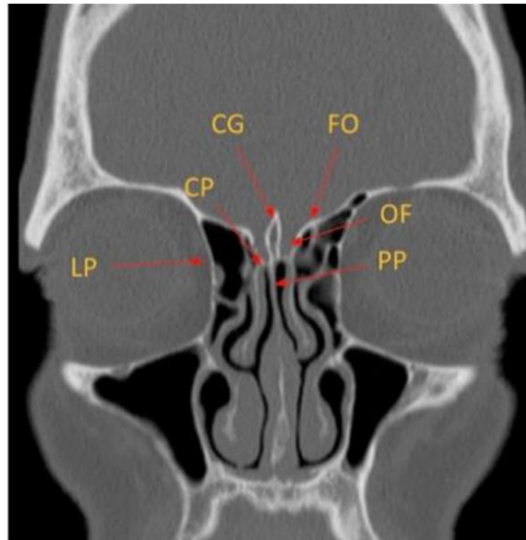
Coronal CT image depicting the key anatomy of the ethmoid bone. CG: Crista galli; FO: fovea ethmoidalis; CP: cribriform plate; OF: olfactory fossa; LP: lamina papyracea; PP: perpendicular plate of the ethmoid bone; CT: computed tomography.
